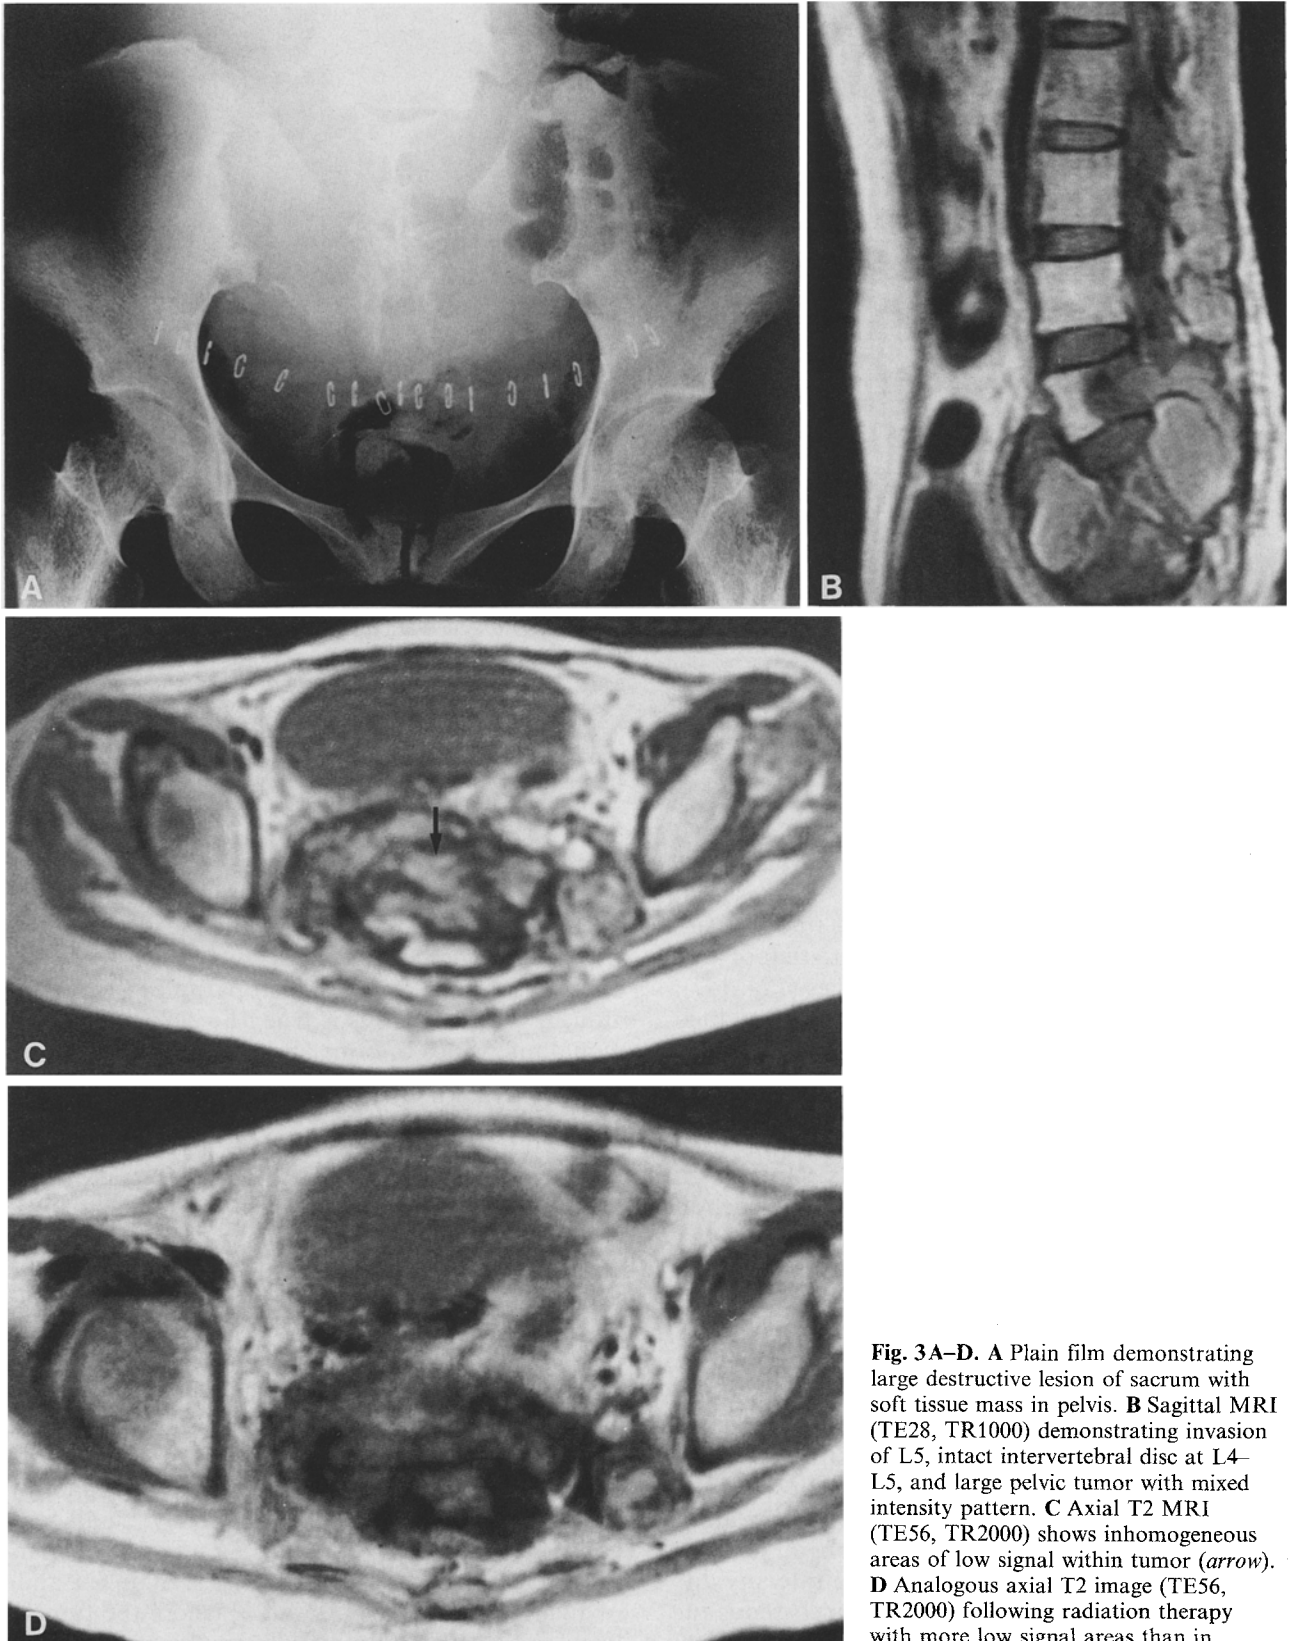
A Plain film demonstrating large destructive lesion of sacrum with soft tissue mass in pelvis. B Sagittal MRI (TE28, TR1000) demonstrating invasion of L5, intact intervertebral disc at L4–L5, and large pelvic tumor with mixed intensity pattern. C Axial T2 MRI (TE56, TR2000) shows inhomogeneous areas of low signal within tumor (*arrow*). D Analogous axial T2 image (TE56, TR2000) following radiation therapy with more low signal areas than in Fig. 3C
